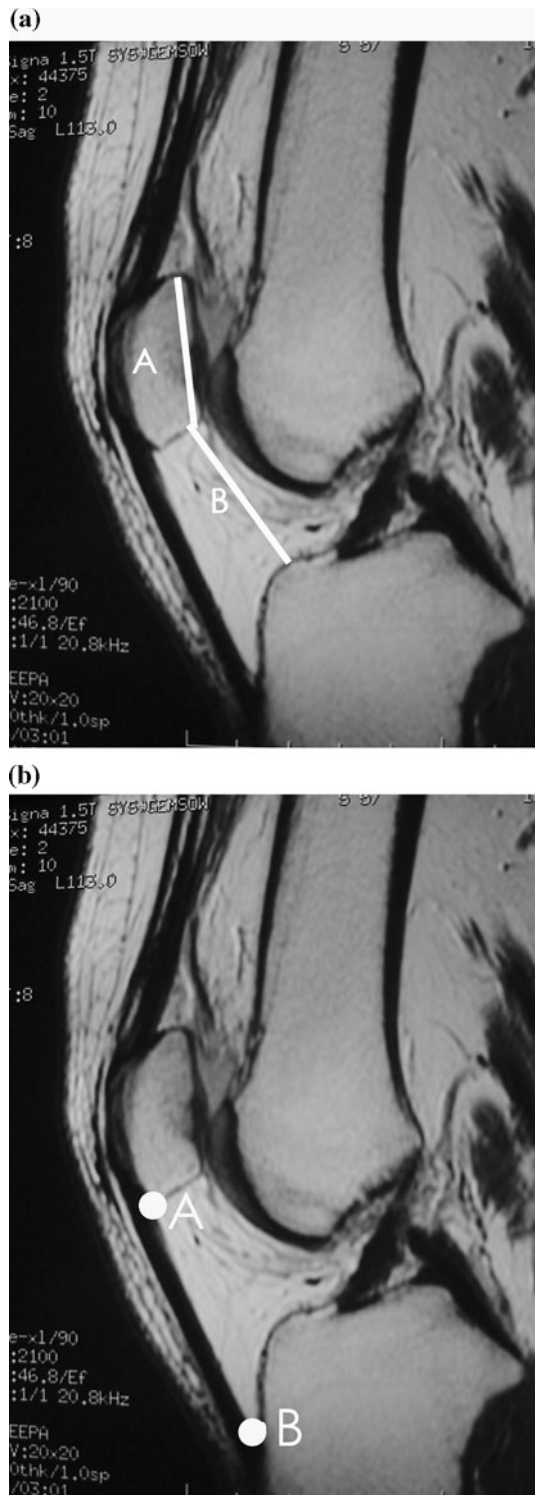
a Measurement of the Caton index on MRI. b Measurement of patellar tendon length on MRI
